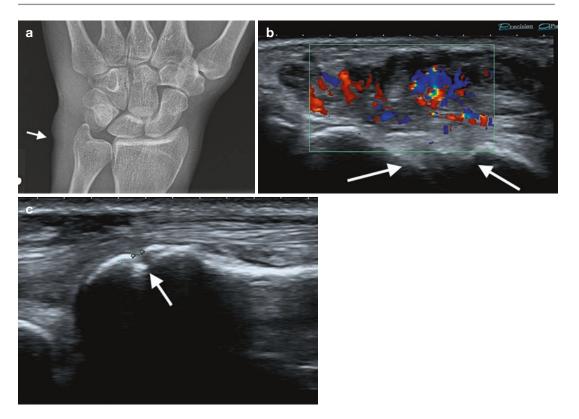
Patient with rheumatoid arthritis. (a) AP radiograph of the wrist with soft tissue swelling over ulnar styloid process with subtle cortical changes. (b, c) Longitudinal
